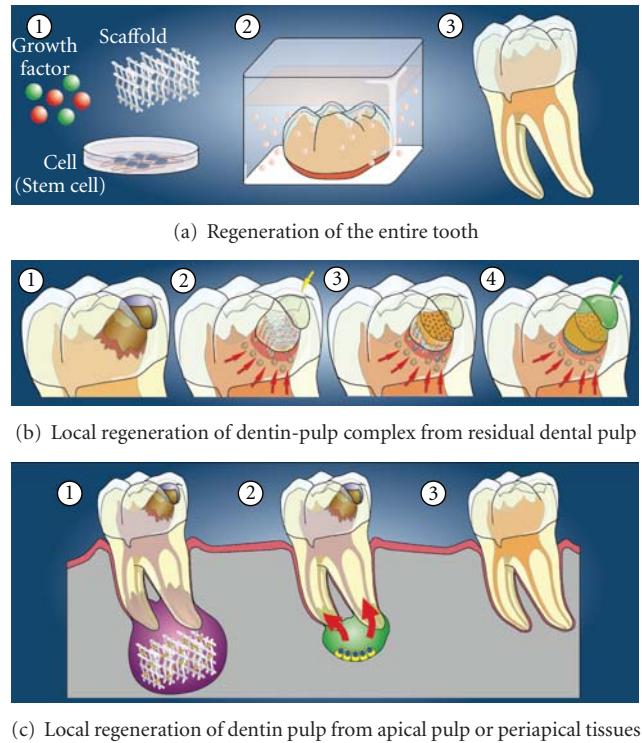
Strategies for regeneration of the dentin-pulp complex with three factors for tissue regeneration; growth factors, scaffolds, and cells (stem cells or progenitor cells). (a) Regeneration of the entire tooth. (b) Local regeneration of the dentin-pulp complex in the dentin defect area from residual dental pulp. (c) Local regeneration of dental pulp from apical dental pulp or periapical tissues.
